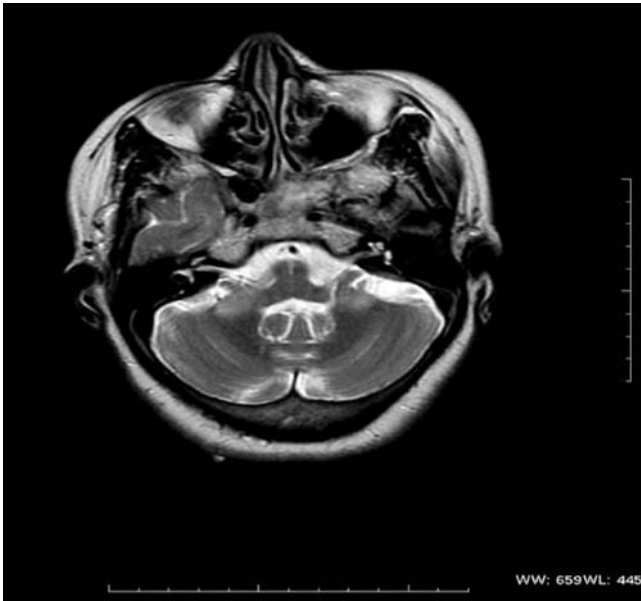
Symmetrical bilateral distribution of high intensity signals in the middle cerebellar peduncles which is unchanged from the previous MRI done 6 months earlier.
